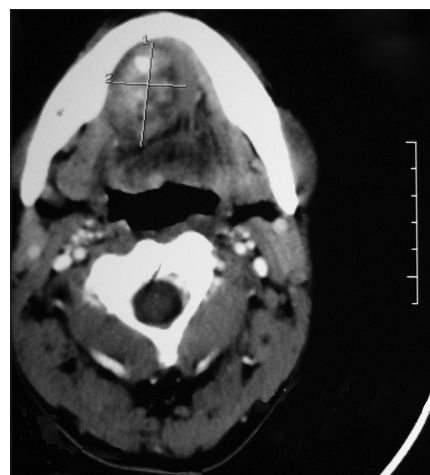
Computed tomography scan in axial view showed a well-defined heterodense mass with specks of calcification in the right sublingual region
